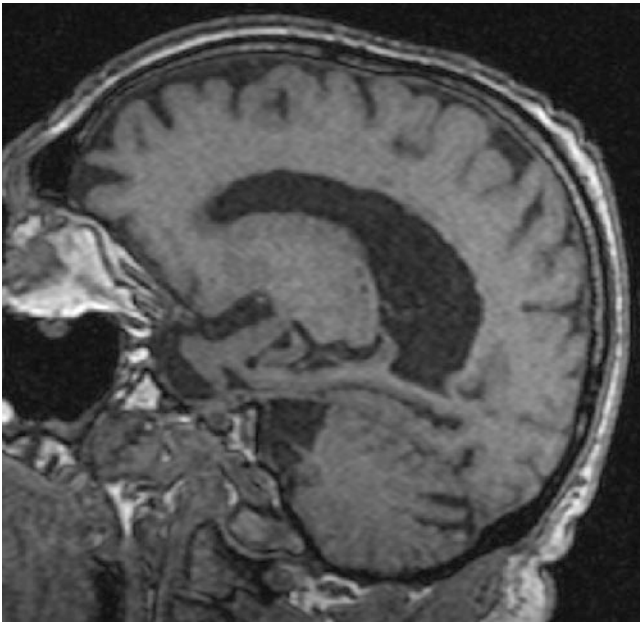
Alzheimer's disease. Sagittal MRI. Atrophy of the medial temporal lobe. (Reproduced with kind permission from Dr. Lisa Tarlinton and courtesy of Nepean Hospital)
